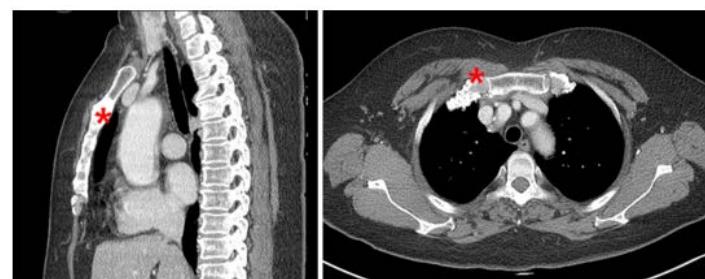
Chest CT shows degenerative changes with sclerosis and subtle subchondral cyst formation at the sternum, manubriosternal joint and right sternoclavicular joint (Asterisk).
